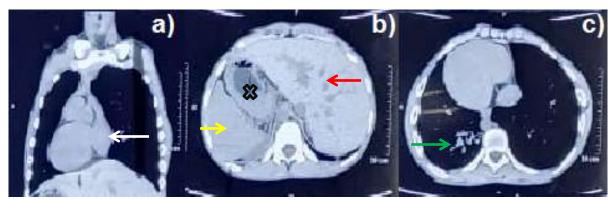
Findings in High Resolution Computed Tomography of the chest
